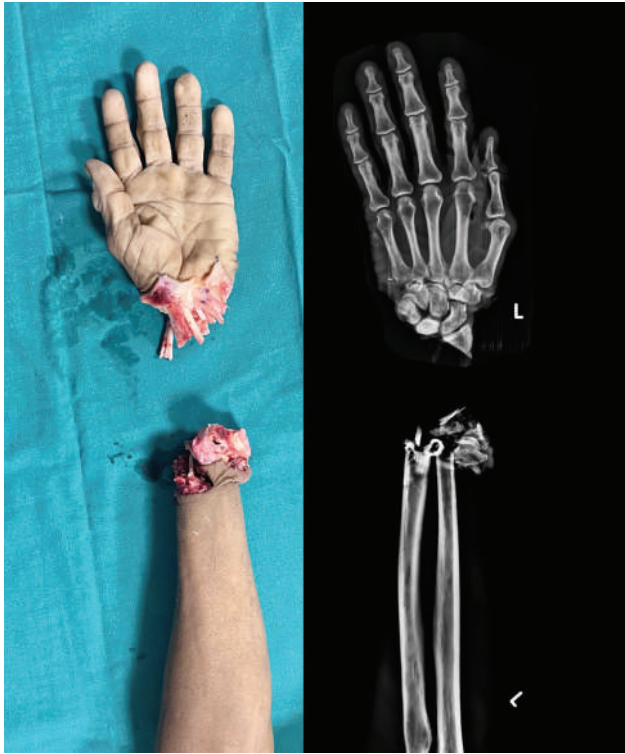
Clinical picture of the amputated left hand at the wrist level with the radiograph at presentation.
